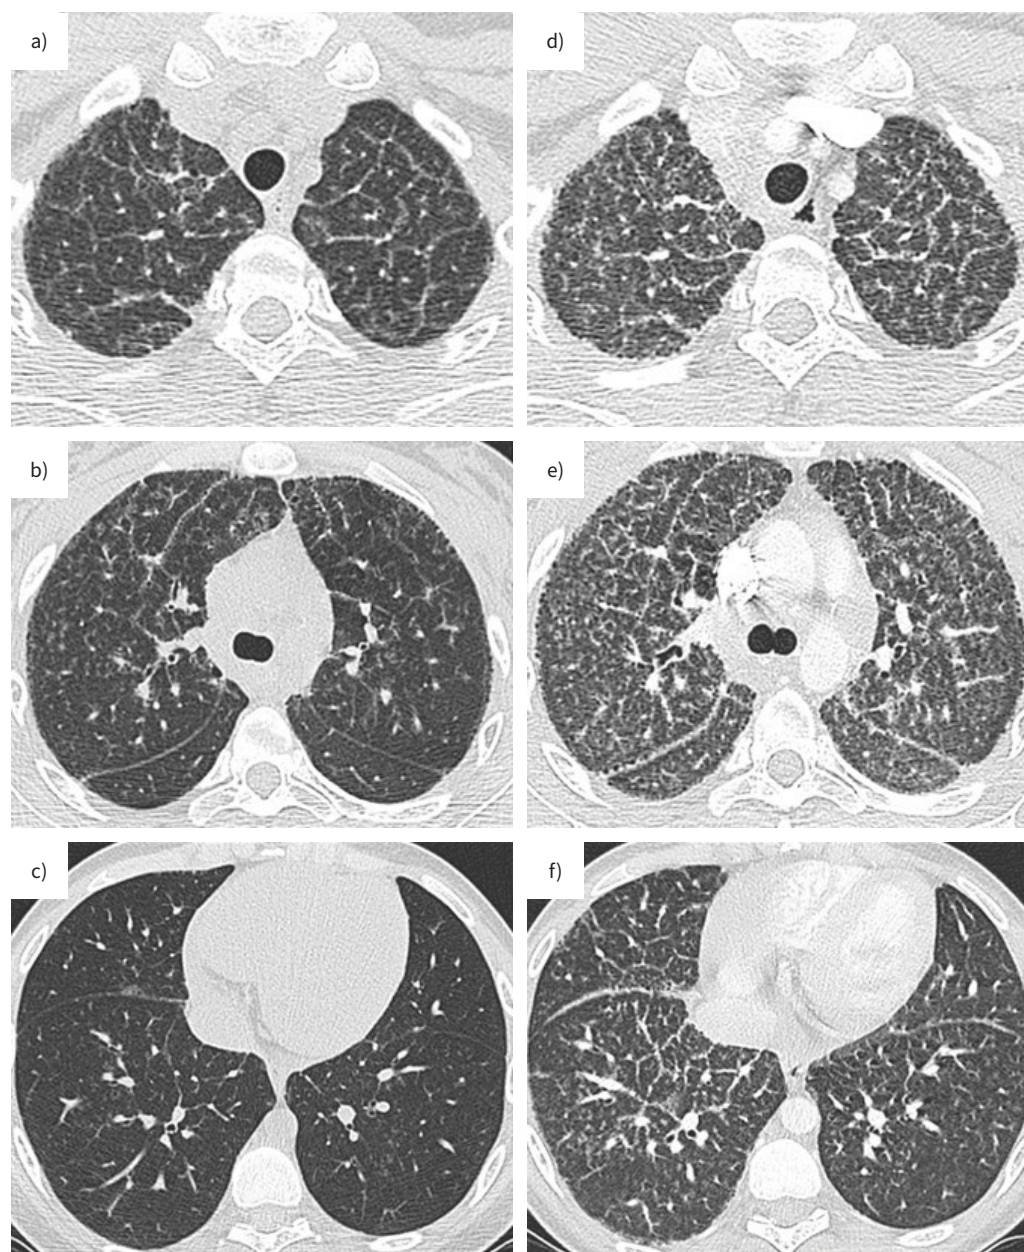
Computed tomography (CT) patterns associated with *GATA2* deficiency. a, b and c) 15-year-old girl with a past history of cytomegalovirus pneumonia in infancy, diagnosed with pancytopenia and myelodysplasia one year before presenting with progressive exertional dyspnoea. The CT scan reveals coarse thickening of the interlobular septa, intralobular lines, initially predominant in the upper lobes. Cystic lesions are observed along the pleura and interlobular septa. Bronchoalveolar lavage suggested alveolar proteinosis. d, e and f) A follow-up CT scan at 18 months showed a worsening of all previously described lesions and the overall extent of the disease, particularly the cystic lesions, that led to the patient's death 2 months later after bone marrow transplantation.
